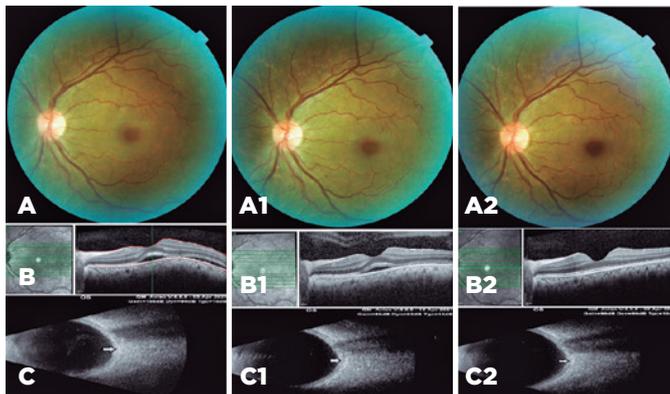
Postoperative findings. (A) Normal fundus image on the first postoperative day. (B) Optical coherence tomography shows subretinal fluid on the first postoperative day. (C) Orbital ultrasonography shows the disappearance of the T-sign (indicated by arrow) on the first postoperative day. (A1) Normal fundus image at the first postoperative week. (B1) Optical coherence tomography shows minimal subretinal fluid at the first postoperative week. (C1) Normal orbital ultrasonography image, showing the disappearance of the T-sign (indicated by arrow) at the first postoperative week. (A2) Normal fundus image at the third postoperative week. (B2) Optical coherence tomography shows a totally normal macula at the first postoperative week. (C2) Normal orbital ultrasonography image showing the disappearance of the T-sign (indicated by arrow) at the first postoperative week.
